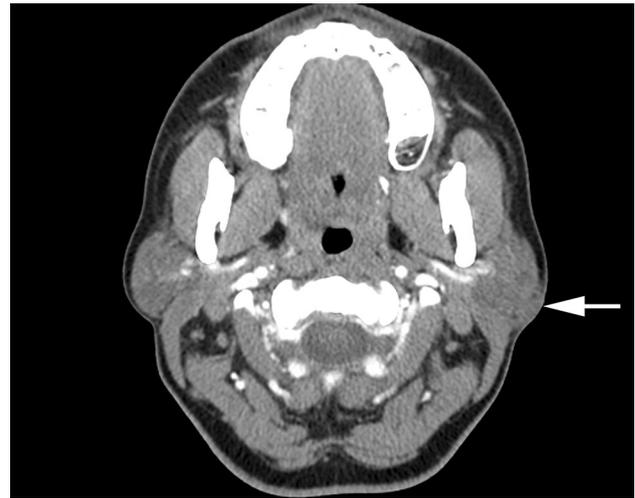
A computed tomography scan of periparotid gland soft tissue enhancement, with extension into the periparotid and subcutaneous soft tissues (arrow)
